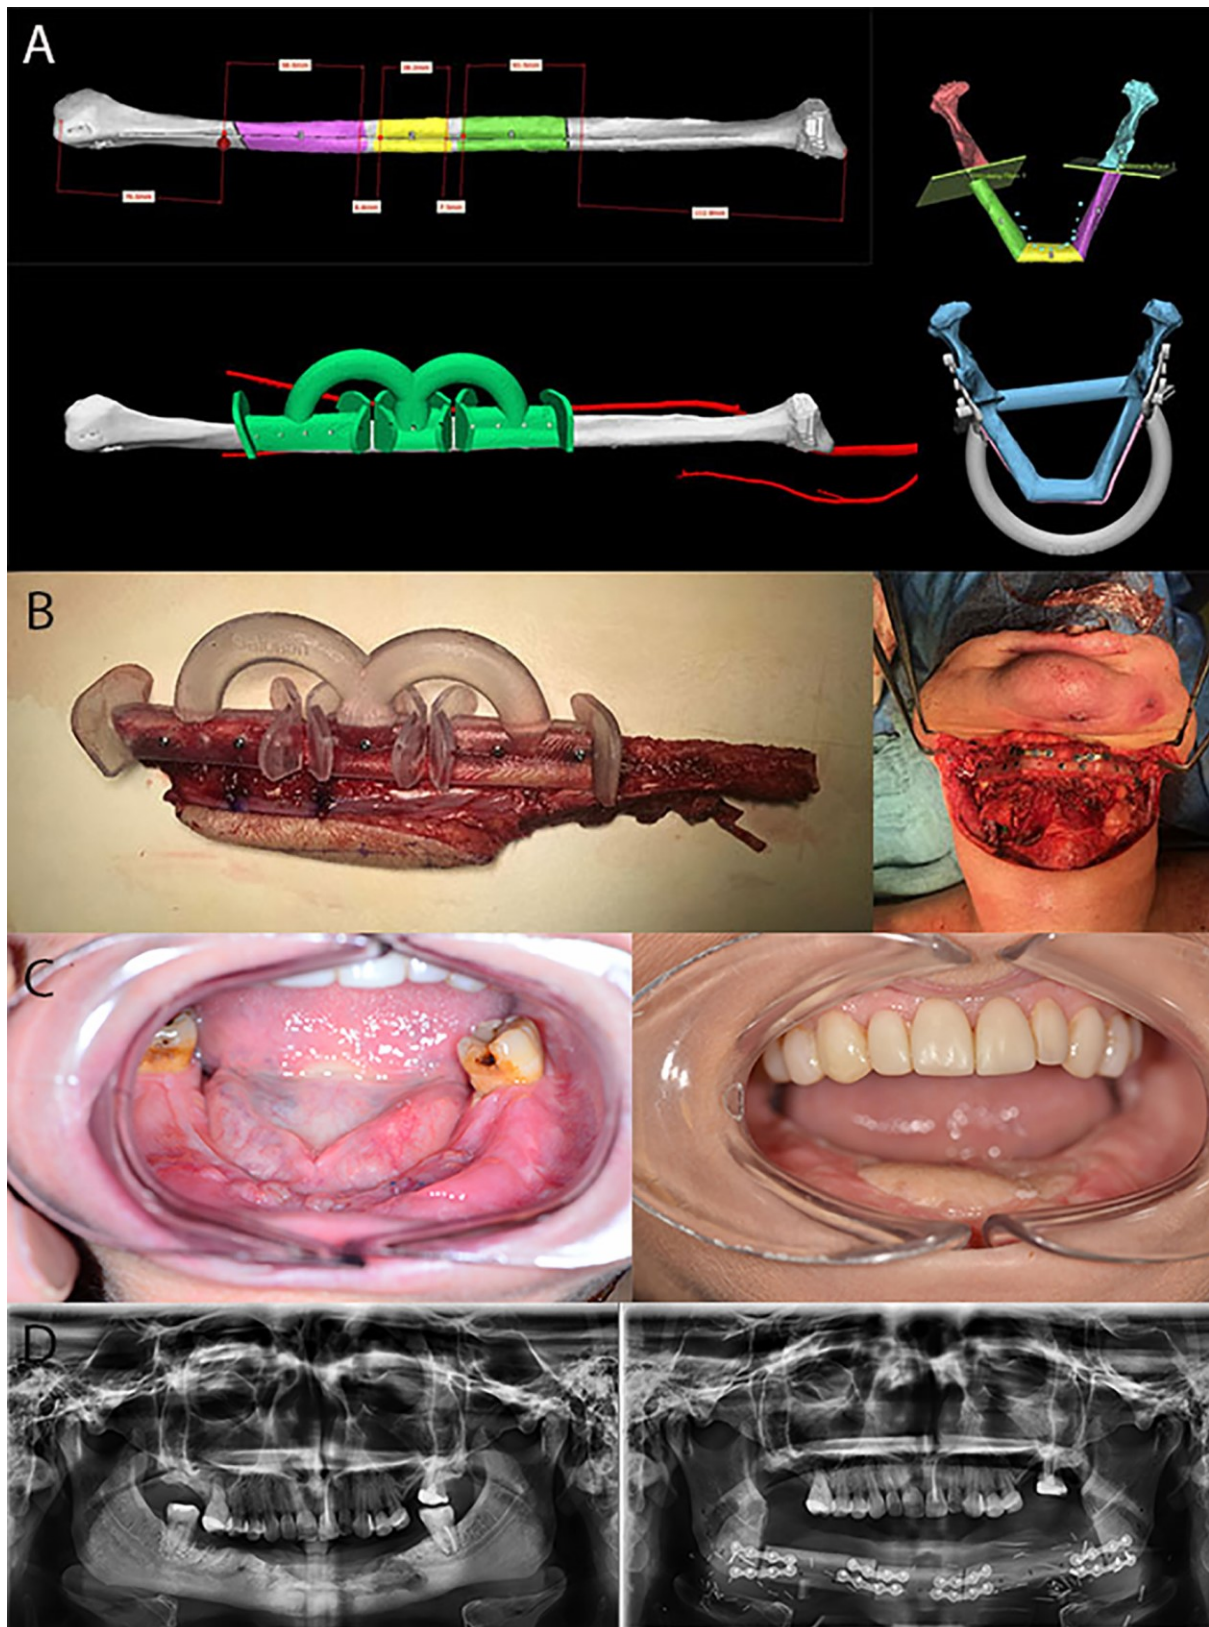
Computer-assisted surgical planning and execution for a squamous cell carcinoma reconstruction. (A) Preoperative virtual analysis and planning. (B) Fibular graft fabrication assisted by guided templates. (C) Preoperative and postoperative intraoral photos of squamous cell carcinoma resection with mandibular reconstruction. (D) Preoperative and postoperative panoramic radiographs.
